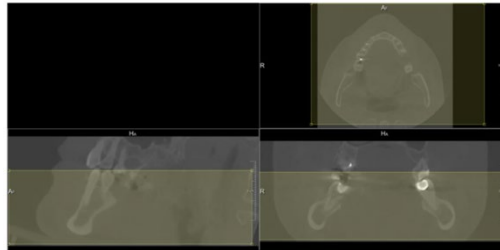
Region of Interest (ROI) selection on CT.*
